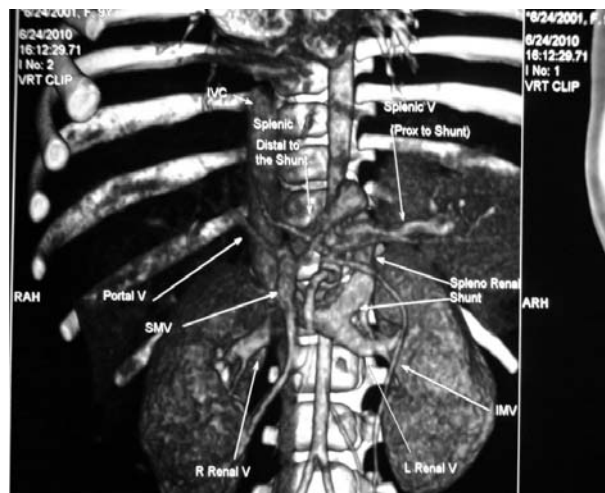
CT renal angiography showing large splenorenal shunt.
